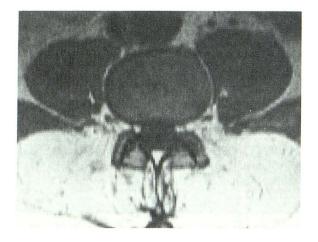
Transaxial T1-weighted MR image (500/35) through lumbar spine of patient with McArdle's disease at L3-L4 level shows grade 3 atrophy of posterior paraspinal muscles with sparing of psoas muscles.
